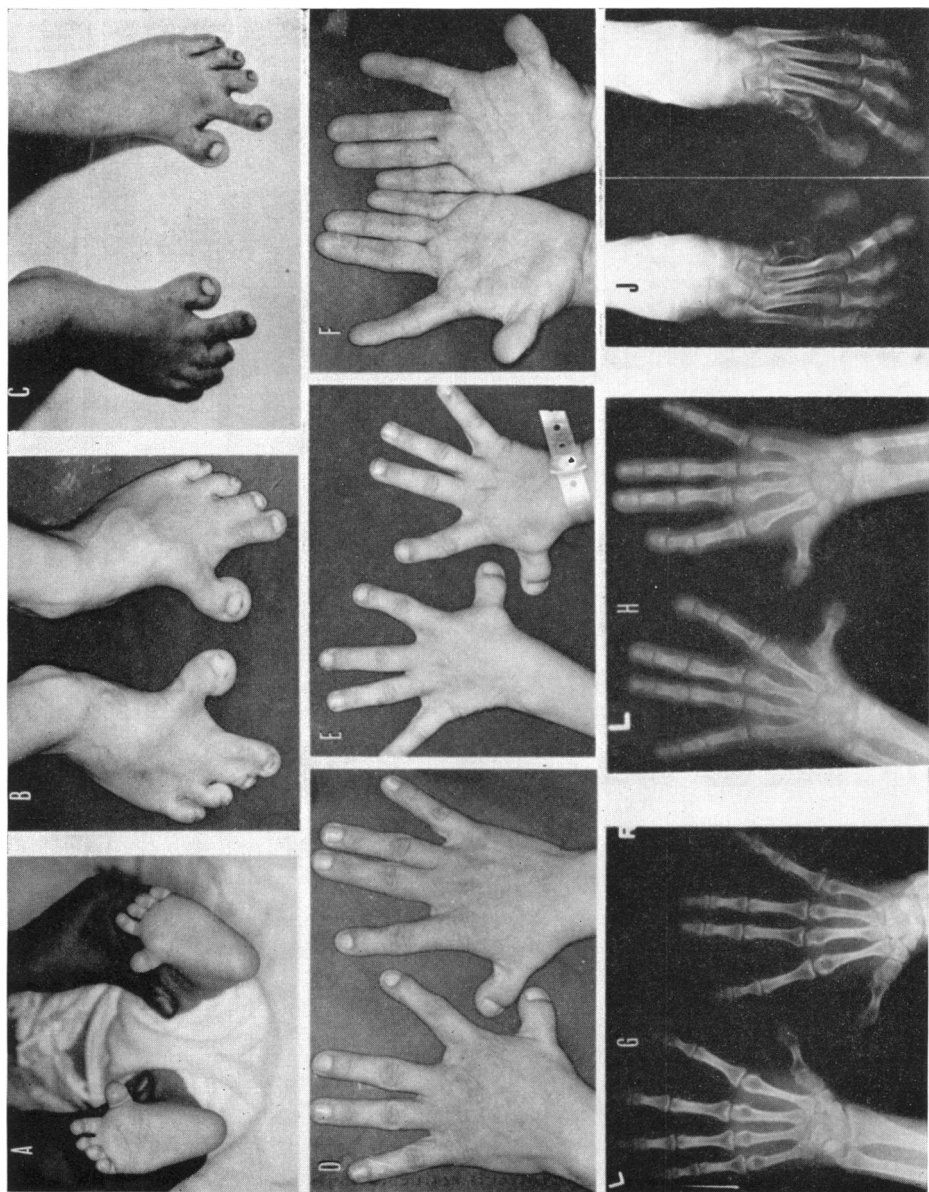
A, Feet of individual V-14, 3 months of age. B, Feet of individual V-6, age 7. C, Feet of individual IV-8, age 29. D, Hands of individual IV-4, age 31. E, Hands of individual V-14, age 6. F, Hands of individual IV-4, palmar view, age 31. G, Hand roentgenogram of individual IV-4, age 31. H, Hand roentgenogram of individual V-6, age 10. J, Foot roentgenogram of individual IV-4, age 31.
